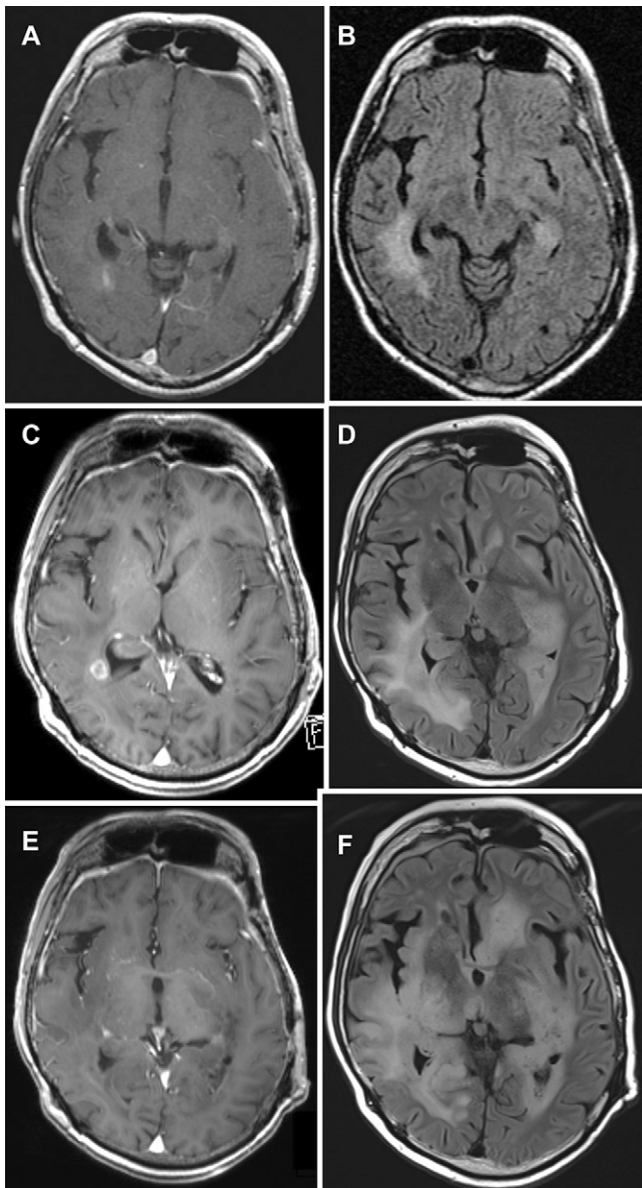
MRI obtained 2, 8, and 18 months after the third resective surgery for tumor recurrence. The enhanced lesion on Gd-T1WI (A) was detected in the right temporal lobe 2 months after the third surgery. The hyperintense lesions on the FLAIR image (B) were enlarged in the right temporal lobe. The enhanced lesion on Gd-T1WI (C) grew in the right temporal lobe during temozolomide treatment 8 months after the third surgery. The hyperintense lesions on the FLAIR image (D) were enlarged in the left hippocampus and the right temporal lobe. No enhanced lesion on Gd-T1WI (E) was detected during ICE treatments 18 months after the third surgery. The hyperintense lesions on the FLAIR image (F) were enlarged in both cerebral hemispheres, which showed massive tumor invasion.
